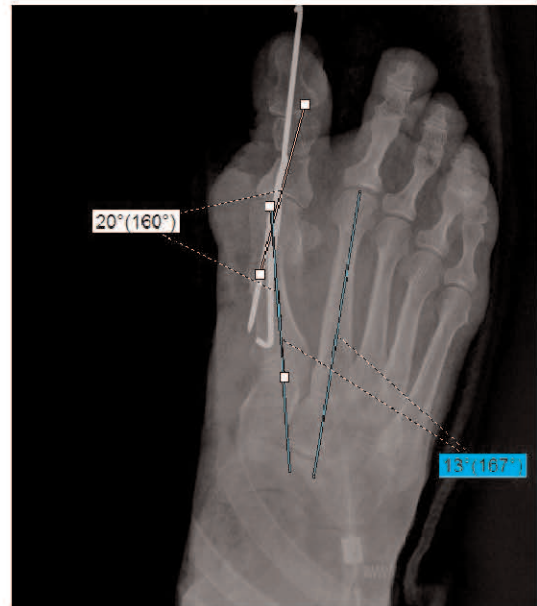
Postoperative antero-posterior x-ray radiography of the same patient. The hallux valgus angle improved by 20° and intermetatarsal angle improved by 13°.
